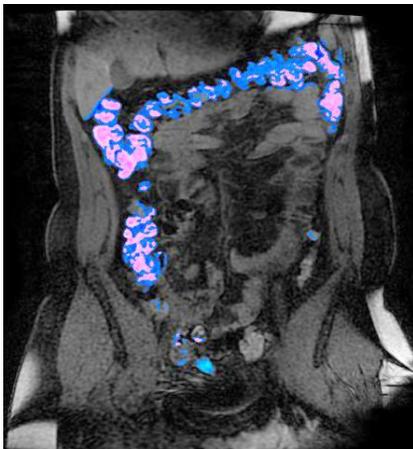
Faecal tagging using MR images of colon.
